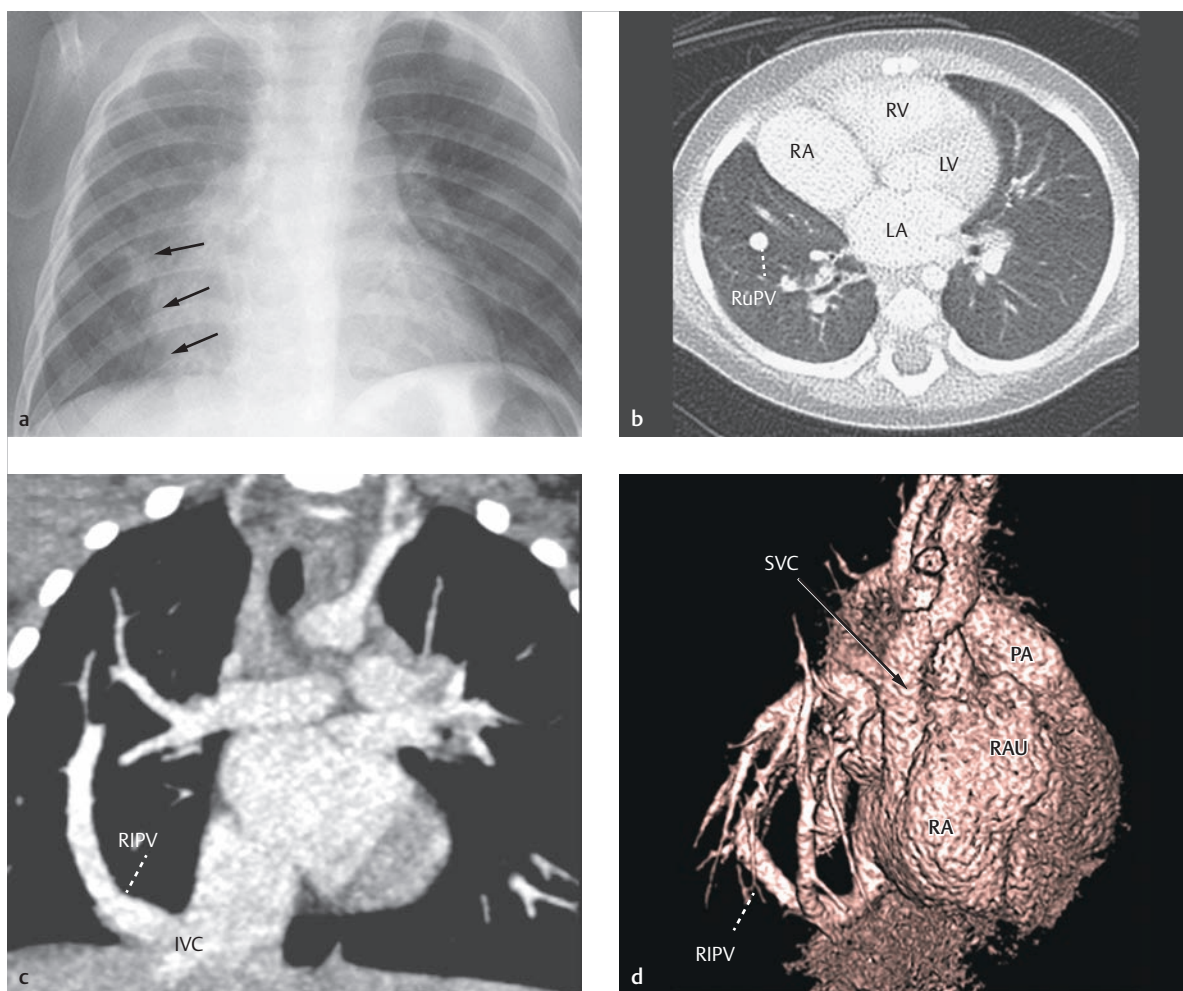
Scimitar syndrome. Nine-month-old female infant. Both the multi-slice CT reconstruction (c) and the volume rendering technique (d) clearly depict the anomalous connection of the right inferior pulmonary vein.
